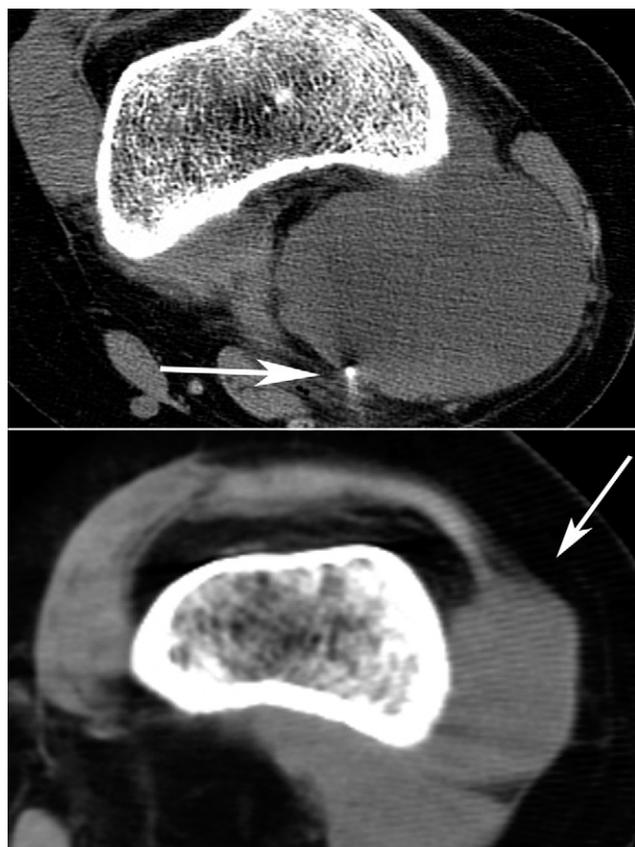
Local tumor recurrence not caused by tumor seeding: axial CT studies of the left distal thigh of a 23-year-old woman with initial biopsy (upper image) demonstrating a large soft-tissue mass in the posterior compartment, with the tip of the biopsy needle identified (arrow); pathologic examination revealed synovial sarcoma. The biopsy needle traversed a posterior approach infiltrating the skin and subcutaneous tissue and entering directly into the mass. Lower image: 14 months later, the patient presented with a local recurrence arising from or invading the vastus lateralis muscle (arrow) in a location clearly separate from the biopsy needle tract.
